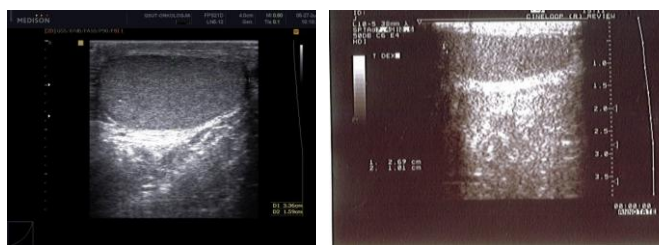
Scrotal ultrasound of two small testes.
